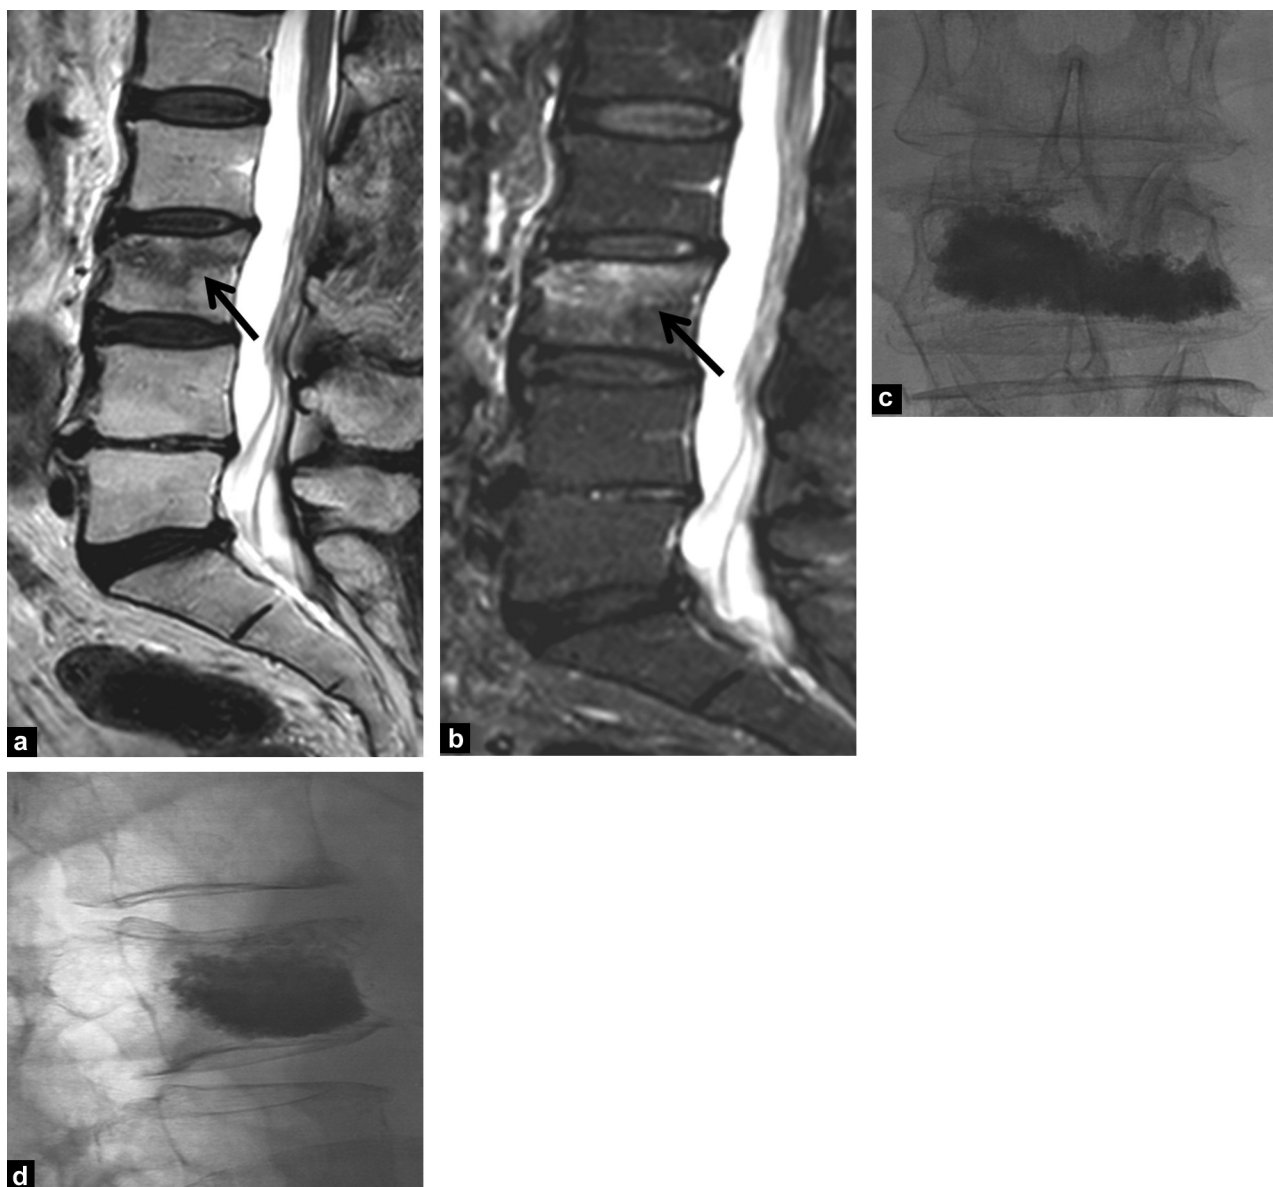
Hypointense metastatic involvement on sagittal T1-weighted image on L3 vertebral body (large arrow) (a) and hyperintense metastatic involvement on STIR sagittal image (large arrow) (b) in a 63-year-old woman with primary colon malignancy before PV. X-rays show metastatic involvement in L3 vertebra confirmed by bone biopsy after PV (c, d).
